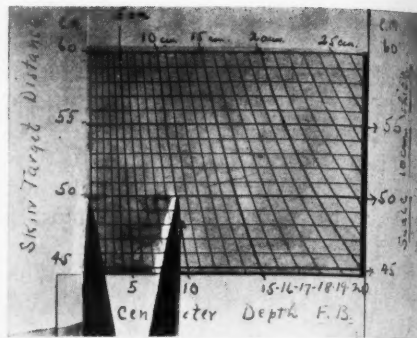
Foreign-body depth scale computations in centimeters applicable for all distances between 45 and 60 cm. focal plate distance; especially adaptable for the radiographic double exposure localization plate or film technic. Milner formula (10-cm. tube shift). Calipers are useful as a measuring device.
